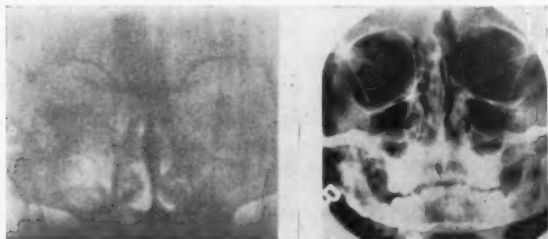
A comparison between a nasal sinus x-ray of 1906 and one of 1953.
